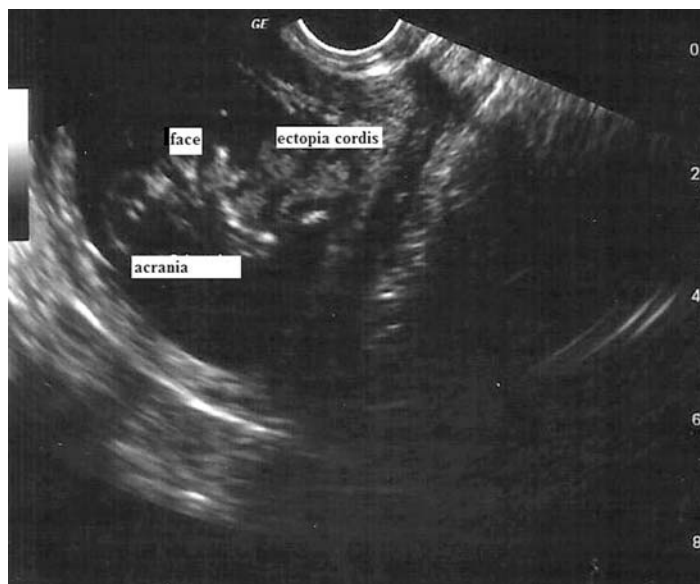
Ultrasonographic view of the fetus
